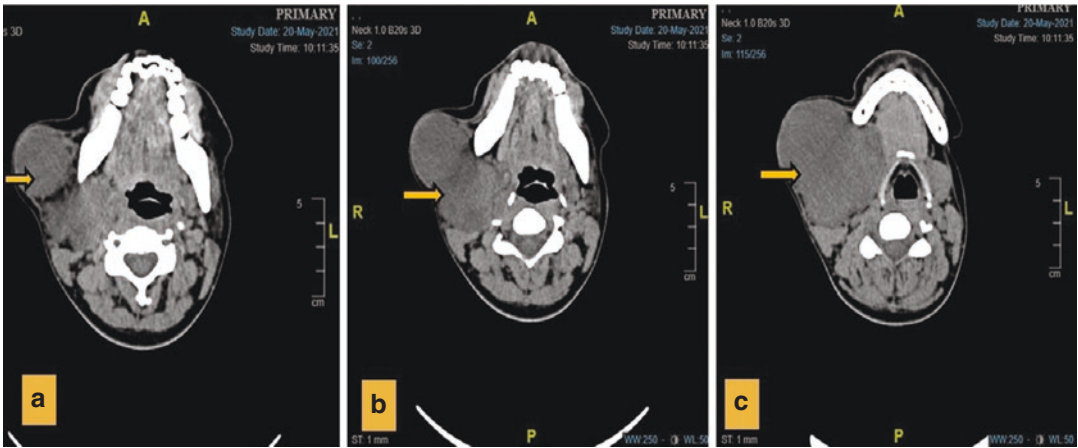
(a) CT scan image showed right submandibular gland mass with medial extension to oropharyngeal airway (b) and abutting the thyroid cartilage (c)
